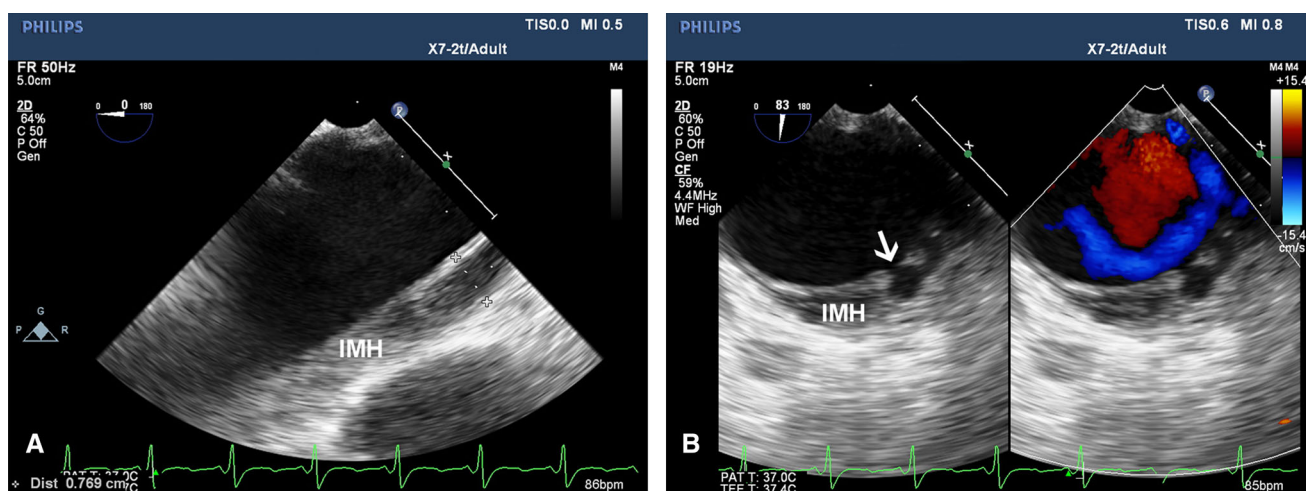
Figure (A) Two-dimensional transesophageal echocardiography performed with an X7 2t Philips ultrasound probe and machine (iE33 model; Philips, Bothell, WA, USA). This upper esophageal, long-axis image depicts an intramural hematoma (IMH) in the distal aortic arch, measuring > 7 mm in thickness. (B) Aortic arch, short-axis view shows a penetrating ulcer overlying the IMH (denoted by an
